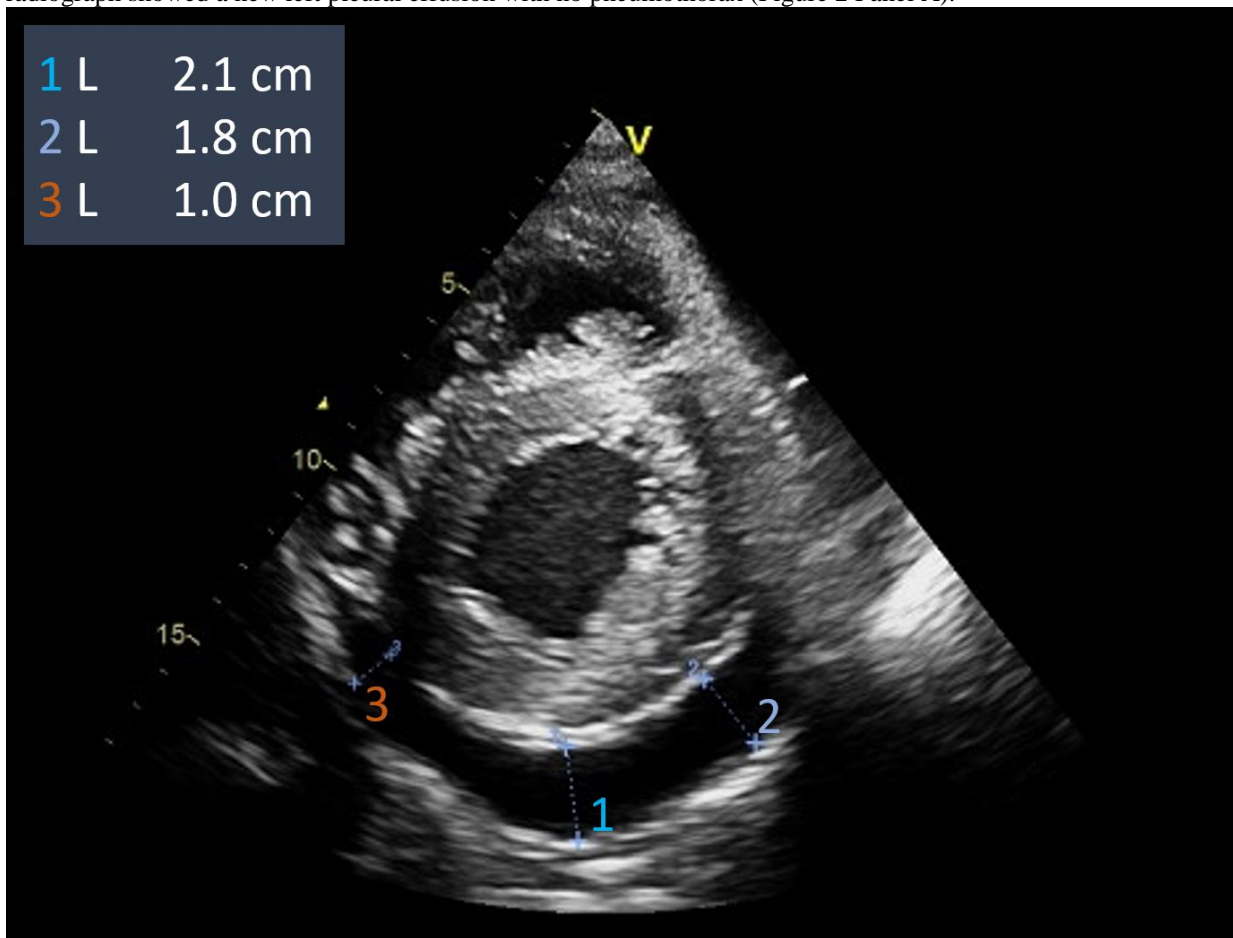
Echocardiogram (parasternal short axis view) demonstrates a global pericardial effusion deepest posteriorly.
